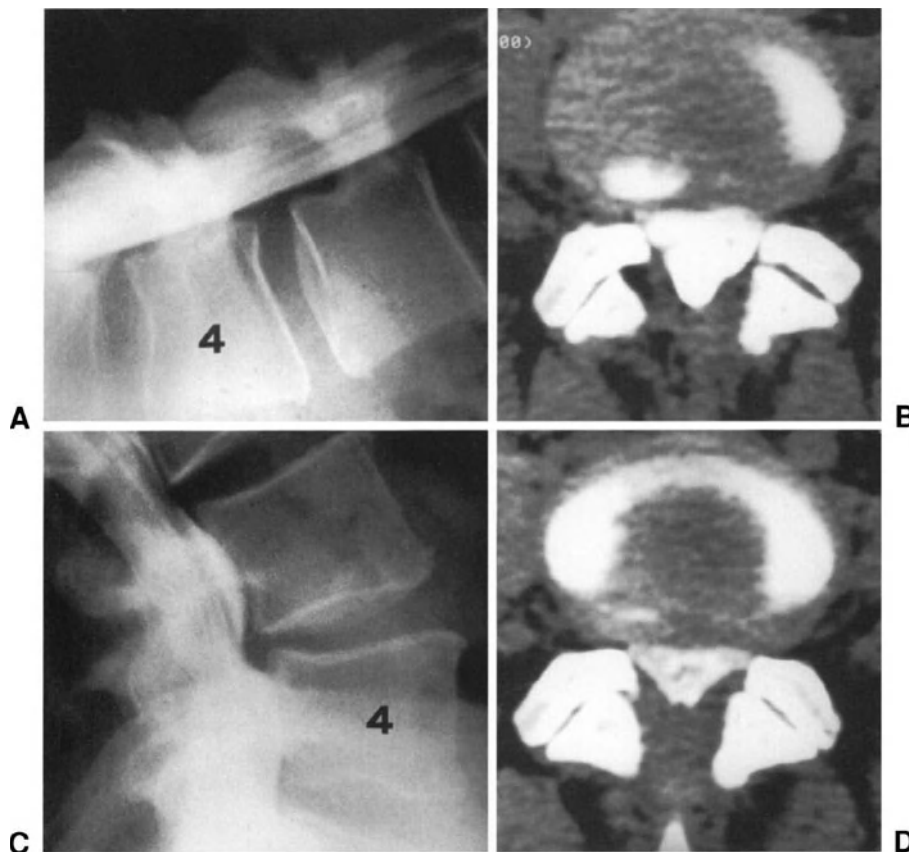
Myelograms and myelo-CT scans at L4-L5 level in flexion (A) and (B), and extension (C) and (D). Myelo-CT scans show a considerable decrease in size of the thecal sac in extension.
